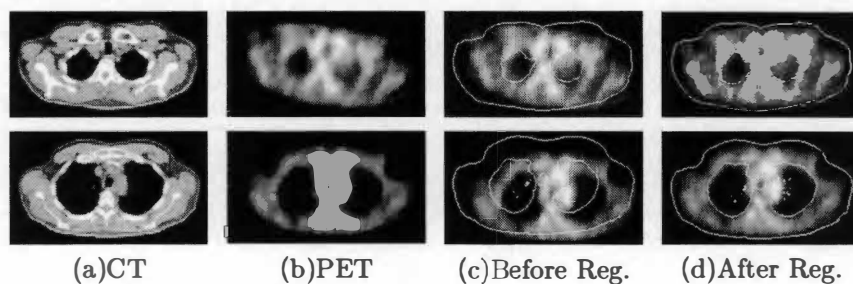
Two pairs of CT/PET images from the first dataset and registration result by the combined mutual information
